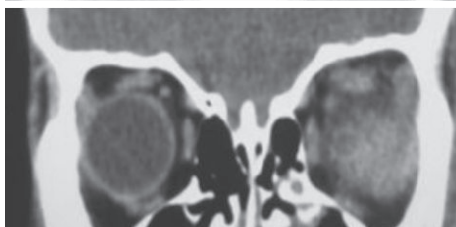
CT scan (coronal view) showing diffuse inflammation in the intraconal and extraconal space of the left orbit.
